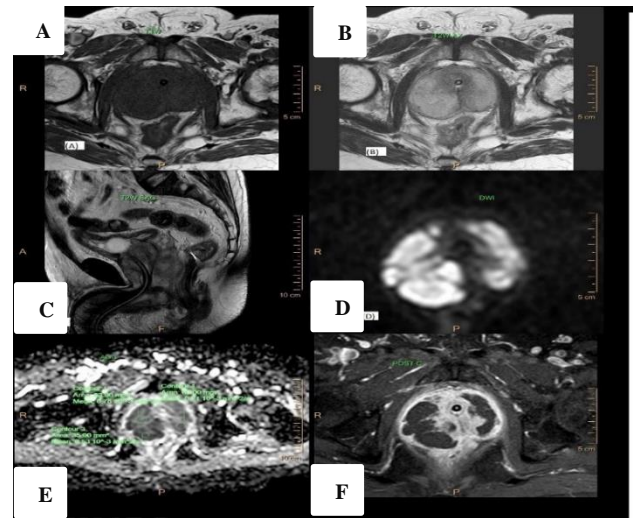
MRI of patient of prostatic abscess, (A) Hypo-intense on T1Wi, (B, C) Hyperintense on T2Wi, (D) DWI showing diffusion restriction, (E) corresponding reduced ADC value, (F) T1FS contrast image showing diffuse peripheral enhancement with non-enhancing central area.
